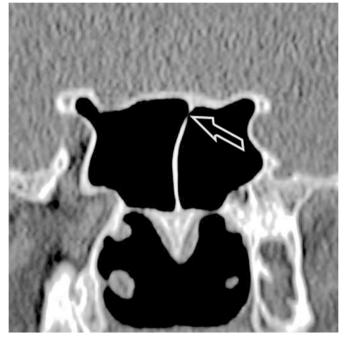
CT of the paranasal sinuses, coronal plane. A partially membranous main septum (the arrow points to the membranous part of the septum).
